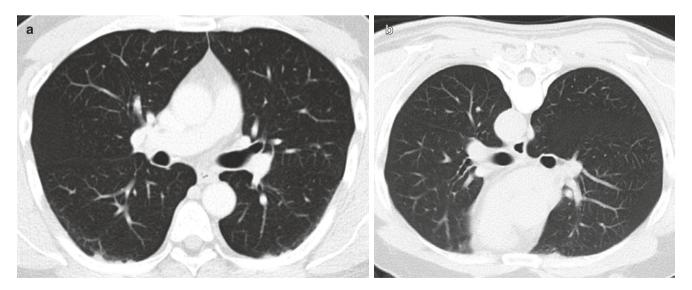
Dependent nodular subpleural atelectasis. (a) Axial supine CT image shows nodular subpleural densities in this staging scan for breast cancer. (b) Prone CT image shows resolution of the dependent changes
